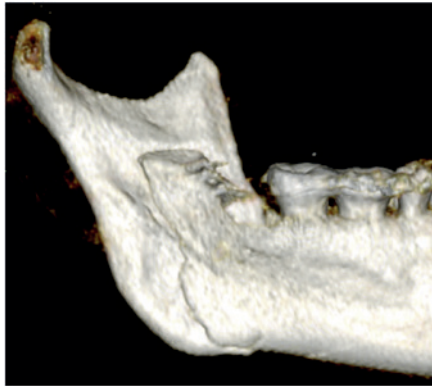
Postoperative cone-beam CT scan of the lingual side after SSO. The fracture line runs through the mandibular foramen and across the mylohyoid groove. Note the position of the medial horizontal osteotomy, just beyond the lingula.
